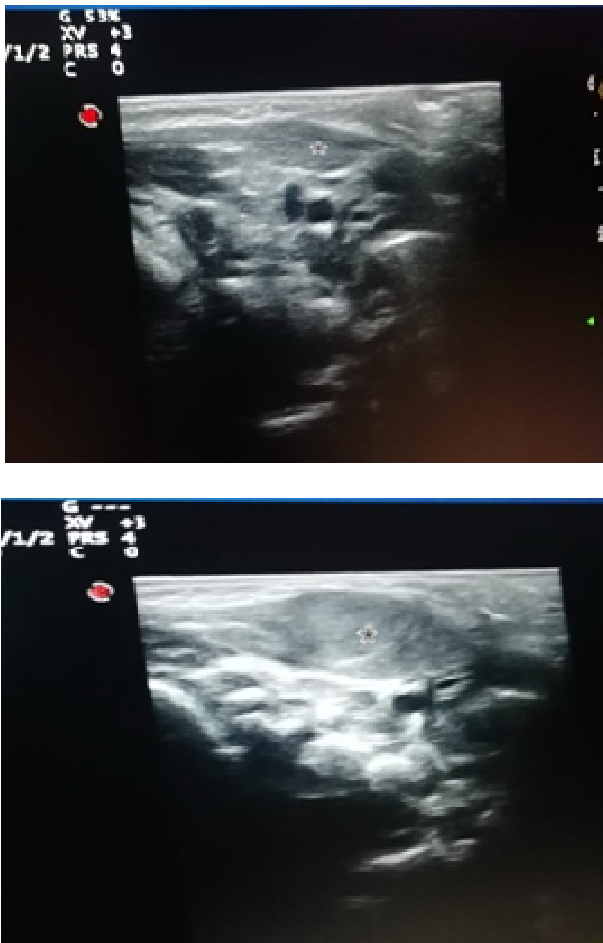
Ultrasound neck showing normal sternocleidomastoid muscle (*) and (b) bulky, fusiform sternocleidomastoid muscle(*)
